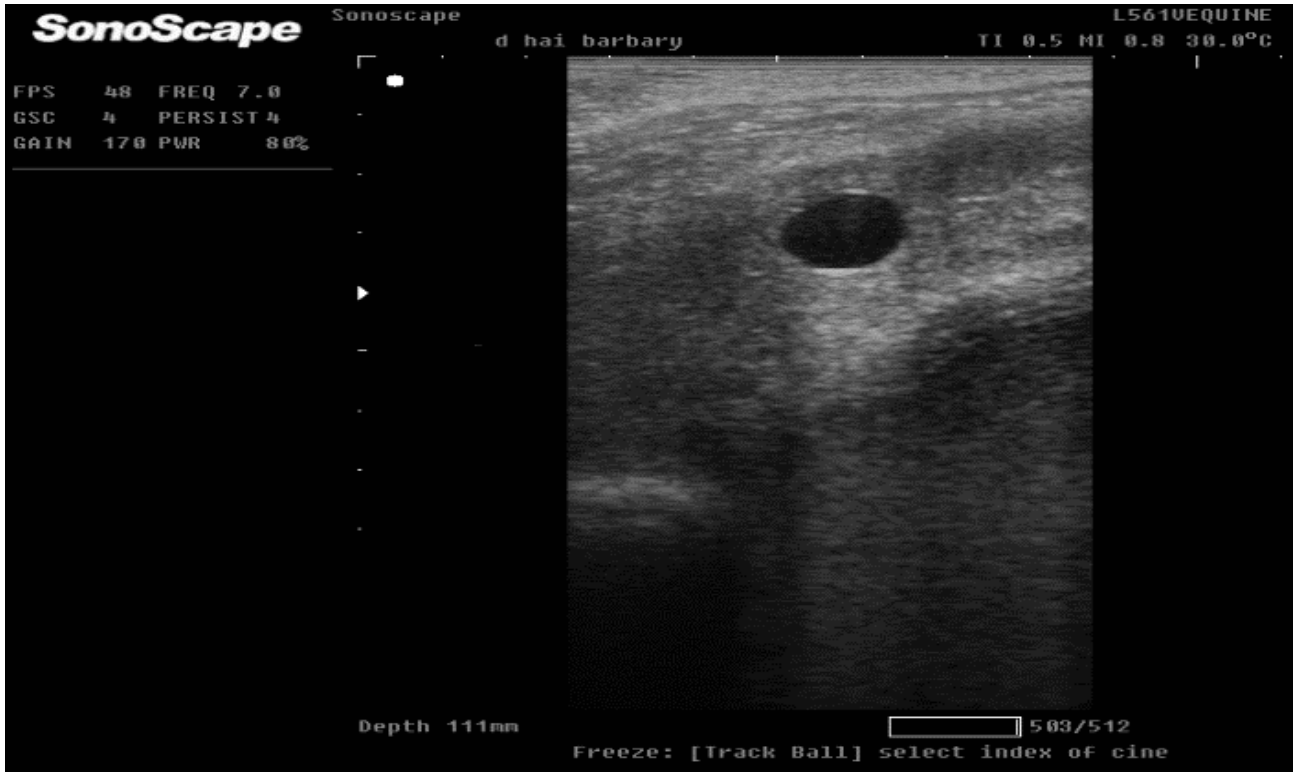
Ultrasonographic image of embryonic sac on day 13 of pregnancy.
